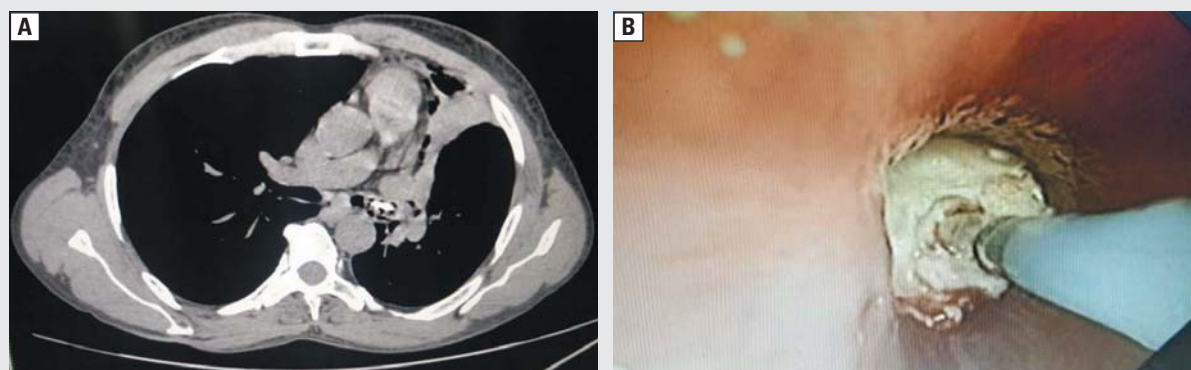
A. CT thorax confirms left upper lobe collapse due to radiopaque foreign body (arrow); B. Flexible bronchoscopy revealed an airway obstruction in the proximal left upper lobe bronchus. The entire granulation tissue along with the tablet was removed with a cryoprobe
